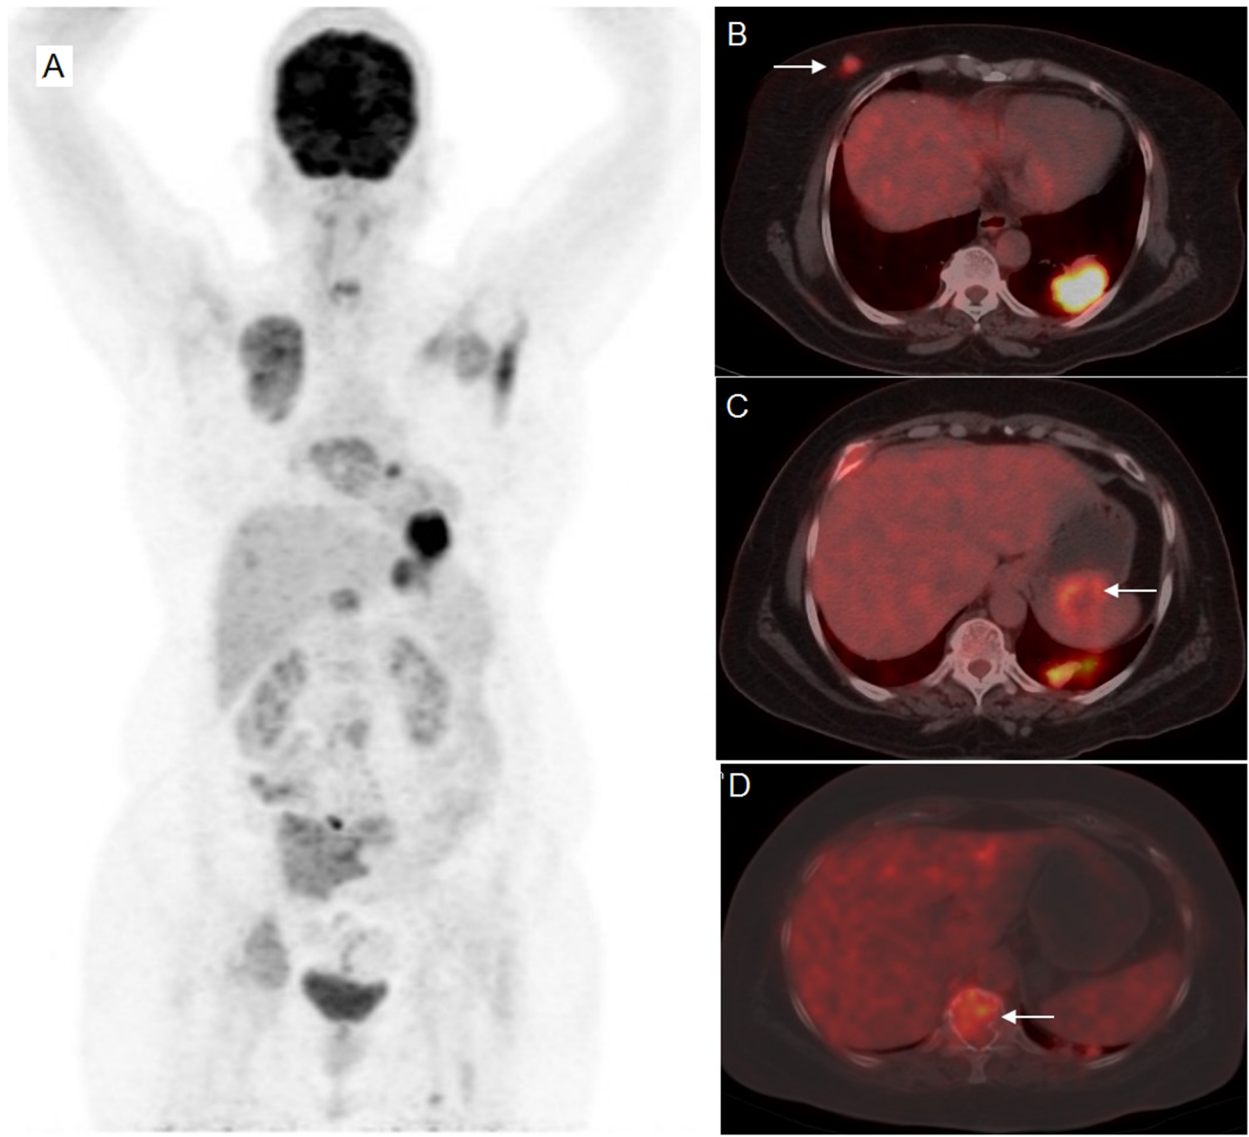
The maximum intensity projection (a), transaxial PET/CT images showing FDG-avid lesions in the right breast (b; SUVmax 3.6), spleen (c) and D12 vertebra (d) (non-avid on the whole-body iodine scan).
